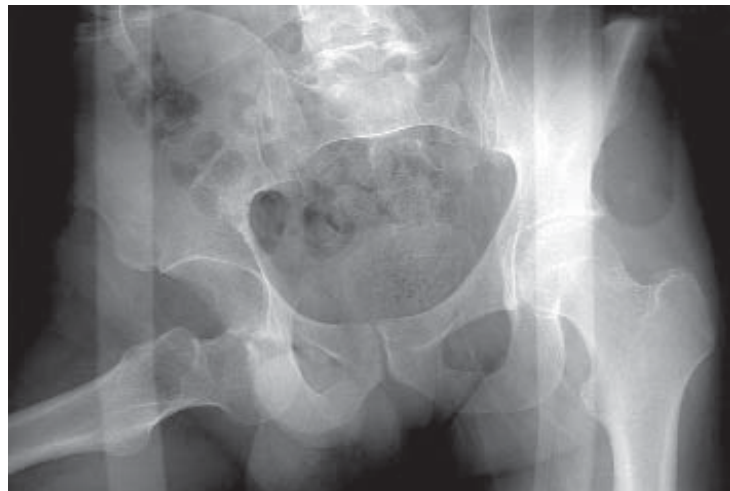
Anteroposterior radiograph of pelvis showed a displaced femoral head in the obturator foramen with marked external rotation and abduction of the femur shaft.
